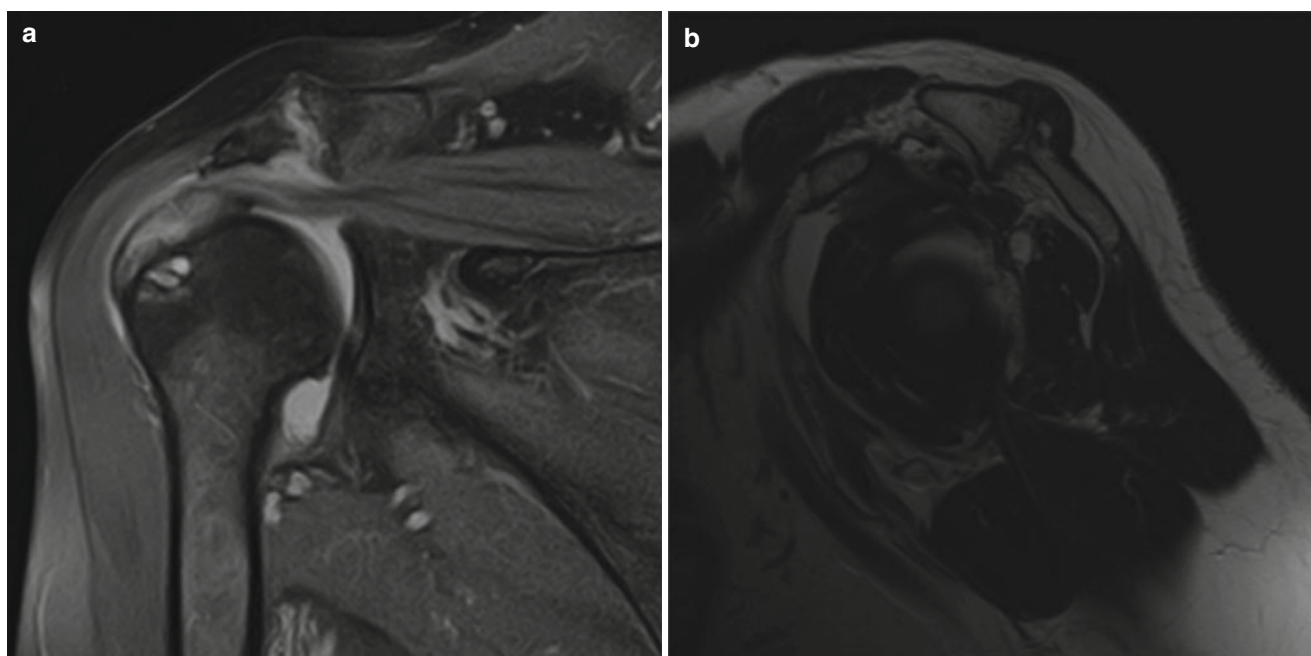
(a, b) MRI scans of 57y male patient showing degenerative changes of the AC joint and of the superior rotator cuff
